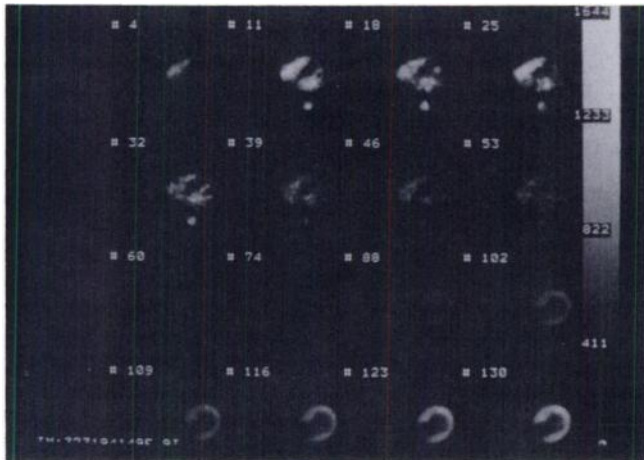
FDG radioactivity images obtained from a dynamic study of a patient with hypertensive diffuse hypertrophy. Frame 4: 0–15 sec; 11: 15–30 sec; 18: 30–45 sec; 25: 45–60 sec; 32: 1 min–1 min 15 sec; 39: 1 min 15 sec–1 min 45 sec; 46: 1 min 45 sec–2 min 15 sec; 53: 2 min 15 sec–2 min 45 sec; 60: 2 min 45 sec–4 min 45 sec; 74: 4 min 45 sec–6 min 45 sec; 88: 8 min 45 sec–10 min 45 sec; 102: 10 min 45 sec–15 min 45 sec; 109: 20 min 45 sec–25 min 45 sec; 116: 30 min 45 sec–40 min 45 sec; 123: 40 min 45 sec–50 min 45 sec; 130: 50 min 45 sec–60 min 45 sec. The activity is first primarily that of right heart, it then shifts to the left ventricle and descending aorta. As blood-pool activity decreases, that of myocardium increases. The time-activity curves for the descending aorta and myocardium were obtained from these images.
